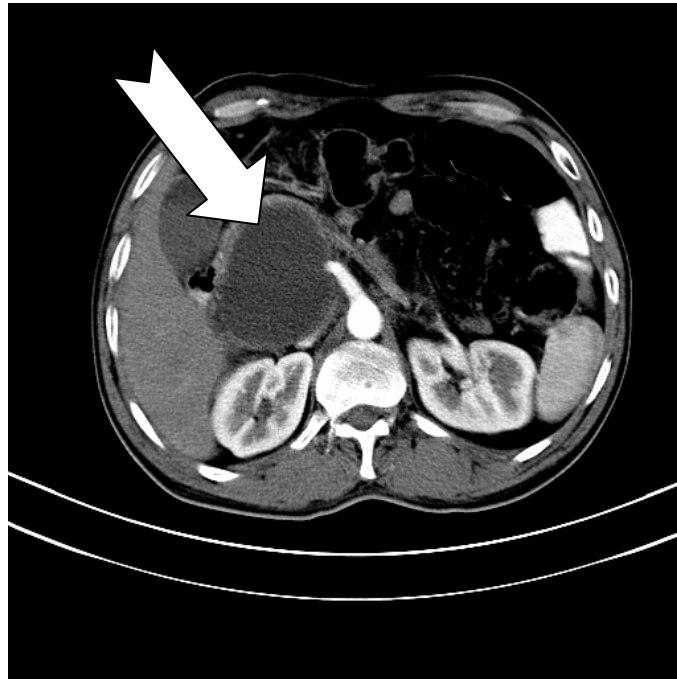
FIGURE # 6 : CONTRAST ENHANCED CT ABDOMEN AXIAL SECTION OF ARTERIAL PHASE SHOWING MULTIPLE LOCULATED COLLECTIONS IN PANCREATIC BODY AND TAIL REGION(ARROW).
